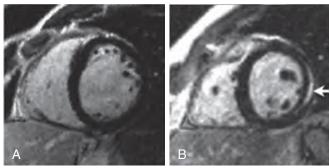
Late gadolinium enhancement magnetic resonance images of the heart. (A) Normal myocardium. (B) Regional, subepicardial enhancement of the lateral wall (arrow). (Modified from Friedrich MG, Sechtum U, Schulz-Menger A, et al. Cardiovascular magnetic resonance in myocarditis. J Am Coll Cardiol. 2009;53:1475–1487.)
